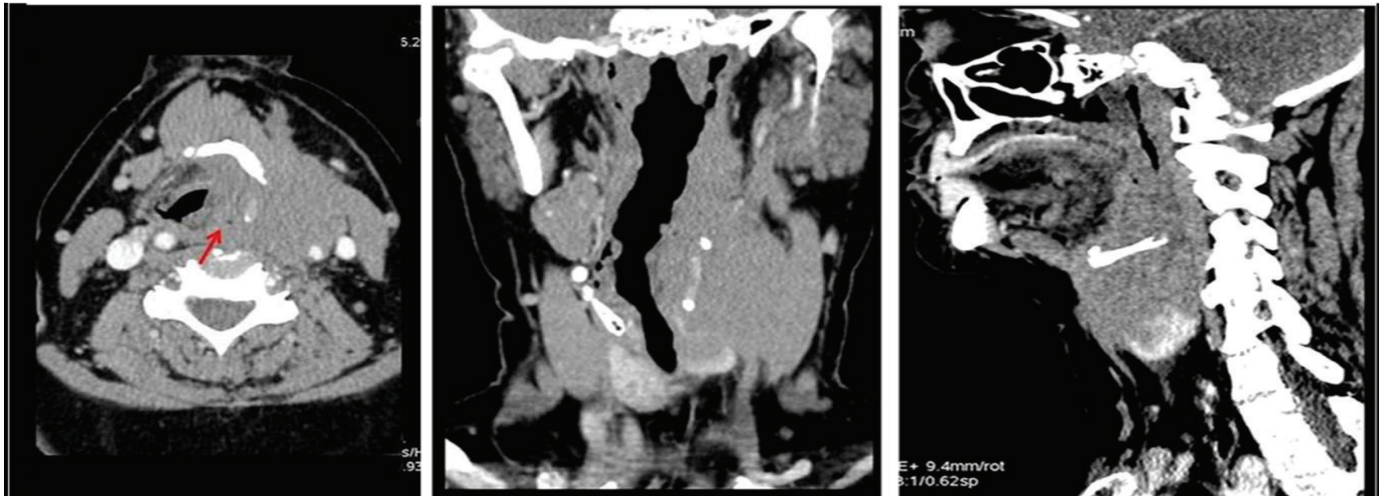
Pre-Chemotherapy CT scan of the patient. (a) Axial CECT scan showing an ill-defined homogeneously enhancing lesion in the left pyriform sinus (red arrow) with extension of the disease into the soft tissues of the neck. (b) Coronal reformat showing lesion in the left pyriform sinus and involving left lobe of thyroid inferiorly. (c) Sagittal reformat showing lesion in the left pyriform sinus and involving left lobe of thyroid inferiorly
